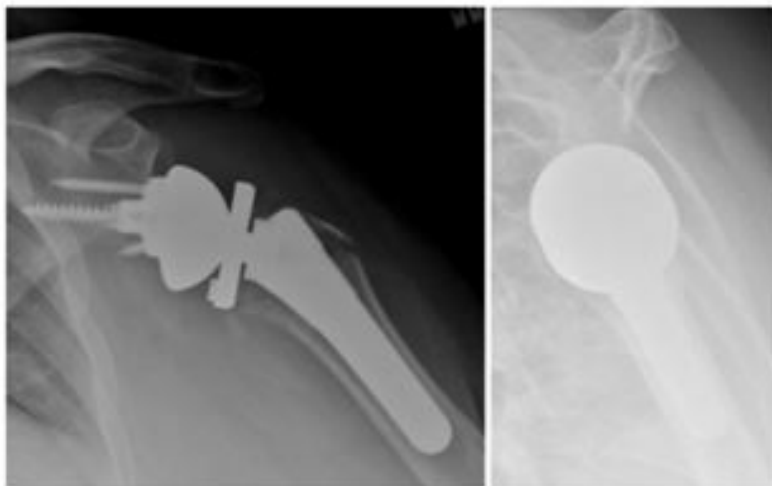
Post operative AP and scapular-Y radiographs of patient 2's left shoulder with rTSA
